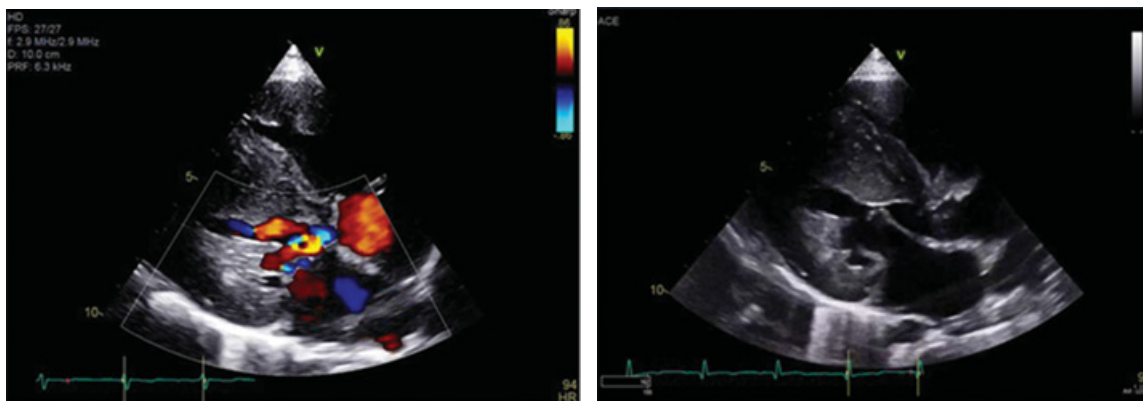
Transthoracic long axis view showing significant flow acceleration at the LV outflow tract (left) and dynamic LV outflow obstruction due to systolic anterior motion of the mitral valve (right). Courtesy of Adam C. Adler, MD.
